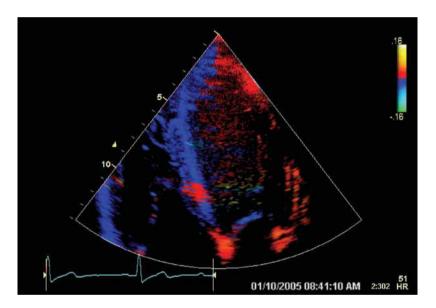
Tissue velocity imaging (TVI). Differential tissue velocities by color Doppler can detect differential contractility of left ventricle (LV) segments—and color coded as shown. This reflects LV dyssynchrony and impaired LV systolic function. (Please *see* companion DVD for corresponding video.)
